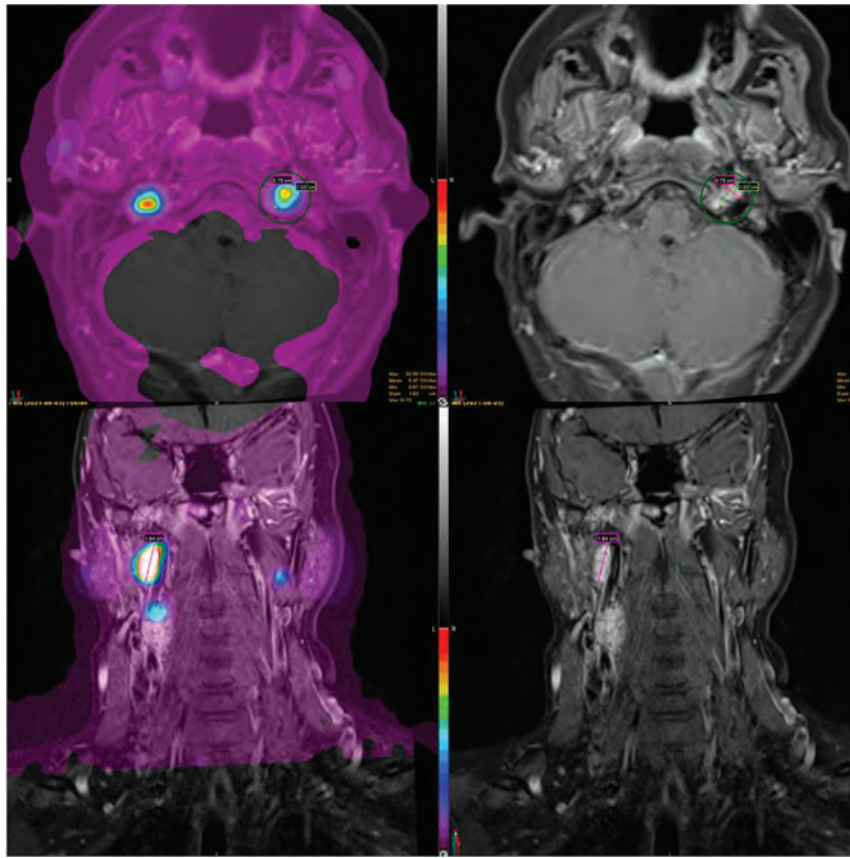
A 31-year-old woman with a vividly enhancing submandibular mass positive for neuroendocrine markers. The patient had SSTR-avid carotid body tumors, a glomus vagale tumor, and glomus jugulare tumors bilaterally. In this example, SSTR-PET/MRI findings were more extensive than on the basis of structural imaging because the right glomus jugulare tumor was not identified on contrast-enhanced MR imaging.
